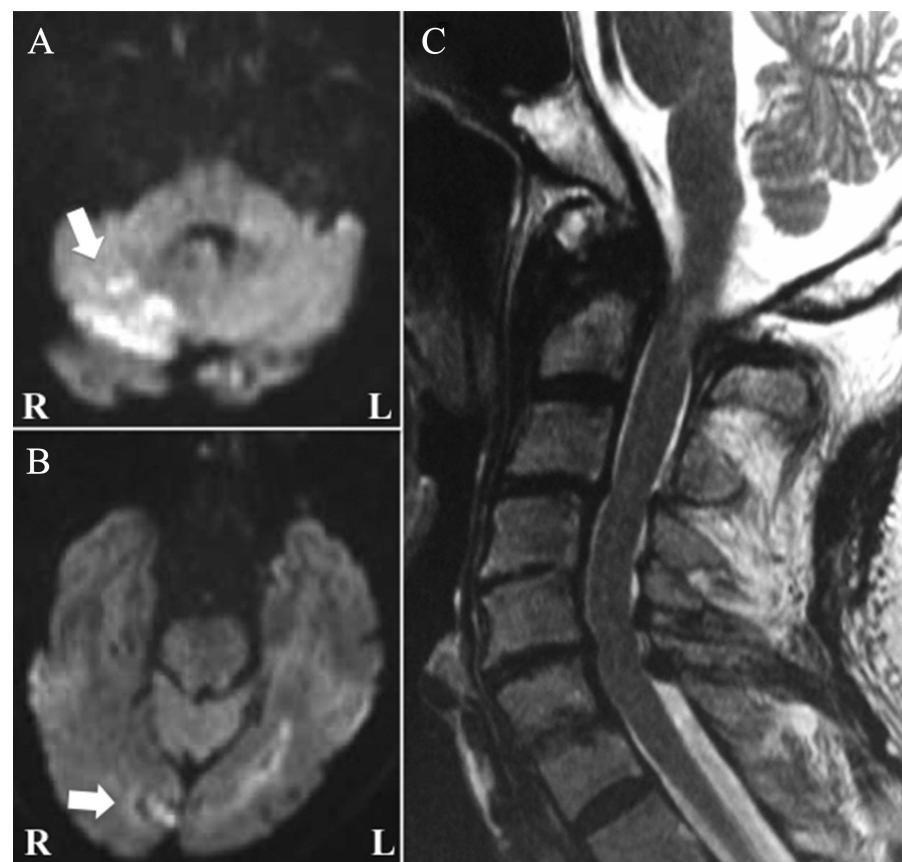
Magnetic resonance images of the brain and cervical spine at onset. A, B, High-intensity lesions in the cerebellum and right occipital lobe on an axial diffusion-weighted image revealing multiple acute infarcts (arrows). C, Destruction of the dens of axis and intramedullary hyperintensity in the upper cervical cord on the sagittal T2-weighted image.
